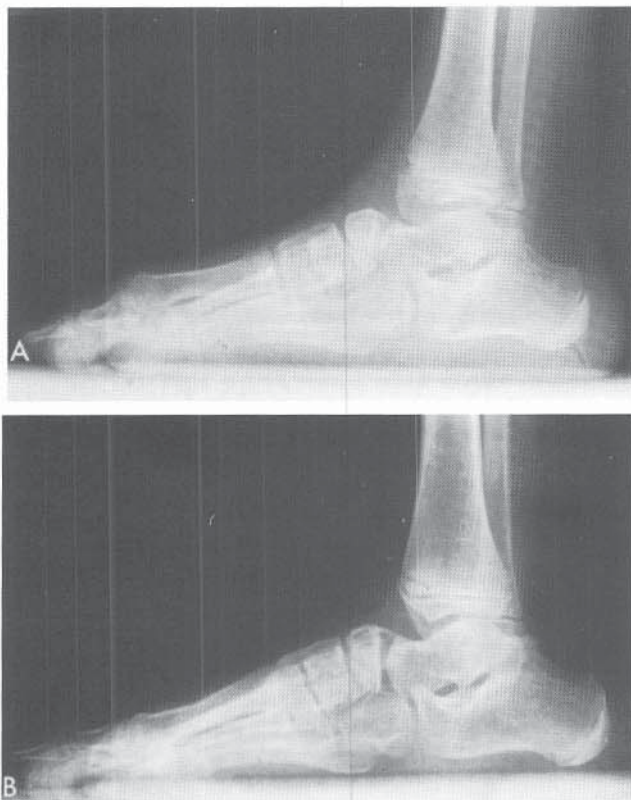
McKay's technique for correction of dorsal bunion. A, Preoperative lateral radiograph of the foot, showing the deformity. B, Postoperative lateral radiograph of the foot. Note the excellent correction. (Courtesy of D. W. McKay, M.D.)
